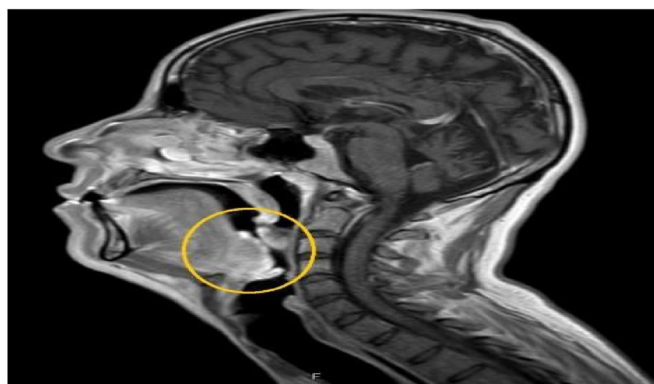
MRI of the mass in the base of the tongue.
